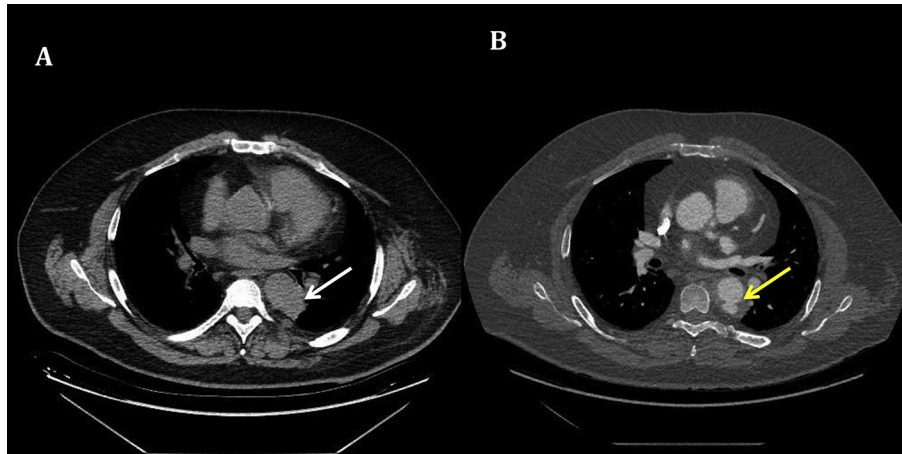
Preoperative computed tomography (CT) images of the chest consistent with aortobronchial fistula (ABF). (A) Unenhanced CT showing mass initially thought to be a neoplasm (white arrow). (B) Enhanced CT showing ABF (yellow arrow).
